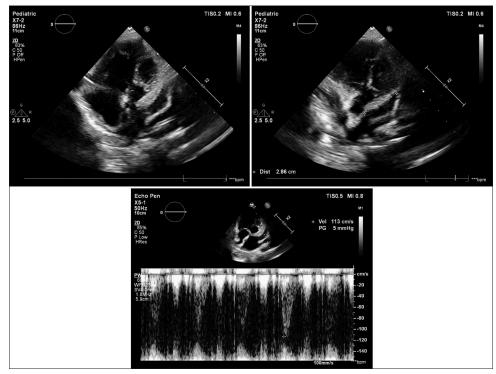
Transthoracic echocardiography images showing la appendage size and velocity
